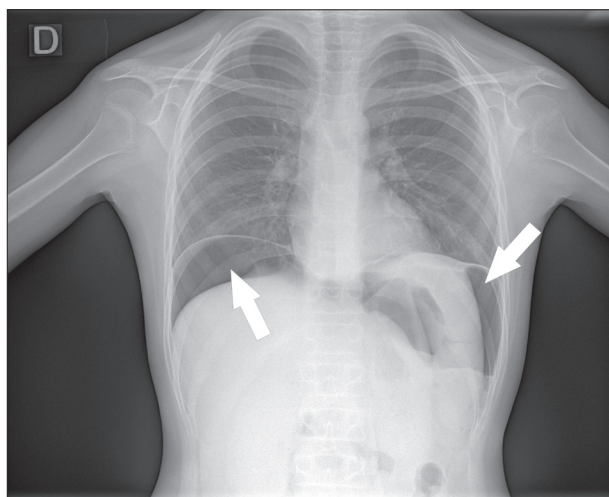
Plain abdominal X-ray image showing hydroaeric levels (arrows)
